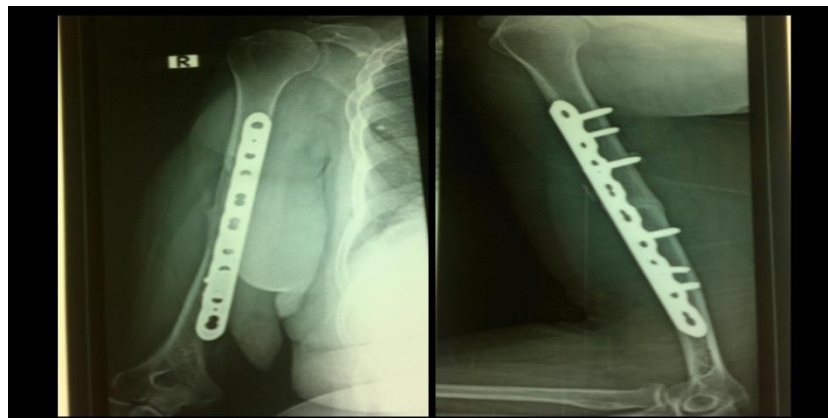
C): X-ray of 6 months follow up showing full union of the fracture
